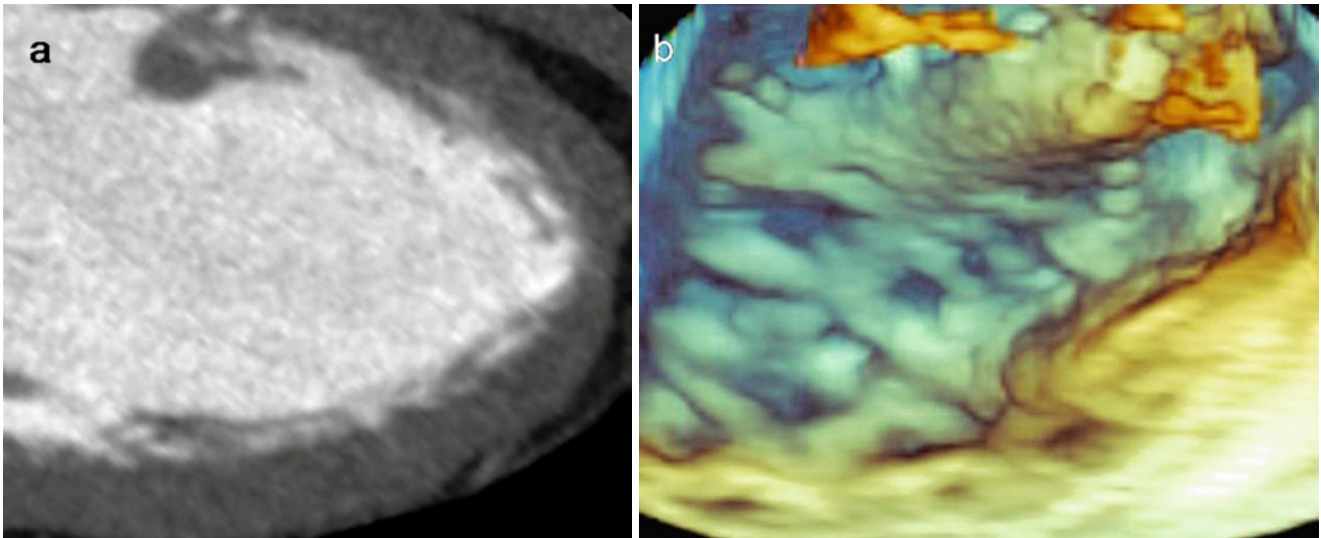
(a) CT slice image and (b) RT 3D TEE showing the fine trabeculation of the apical portion of the *left ventricle*
